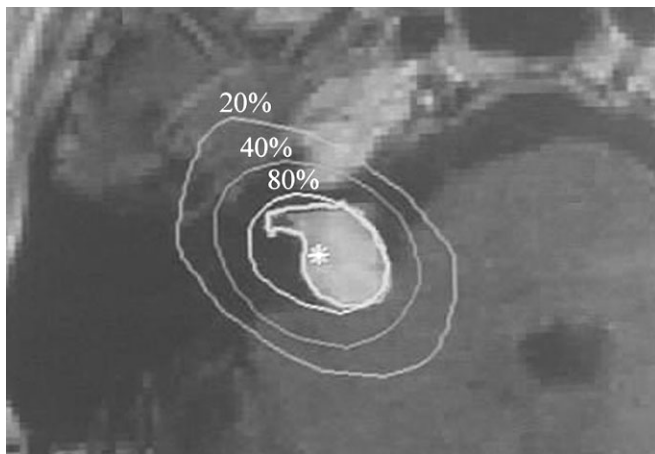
Detail of a stereotactic axial MRI image showing a typical acoustic neurinoma during computerized treatment planning, using a single-isocenter (single shot) radiosurgery plan. By combining different radiation arc spans, angles of arc incidence, and different collimator sizes, a radiation shape tightly conforming to the tumor can be generated. The treatment dose (defined by the 80% circle) closely follows the boundaries of the tumor in the anterior, medial and superior (not shown) aspects of the tumor, where the facial nerve, brainstem, and trigeminal nerve respectively course. The posterior–inferior areas of the tumor are occupied by the lateral cerebellum and the inferior cranial nerves, which are resistant to radiation damage. Note the steep radiation fall-off beyond the tumor margin (the 40% circle represents 50% of the treatment dose, and the outer circle 20% of the treatment dose. The distance between the 50% and the 20% isodose lines is 4 mm).
